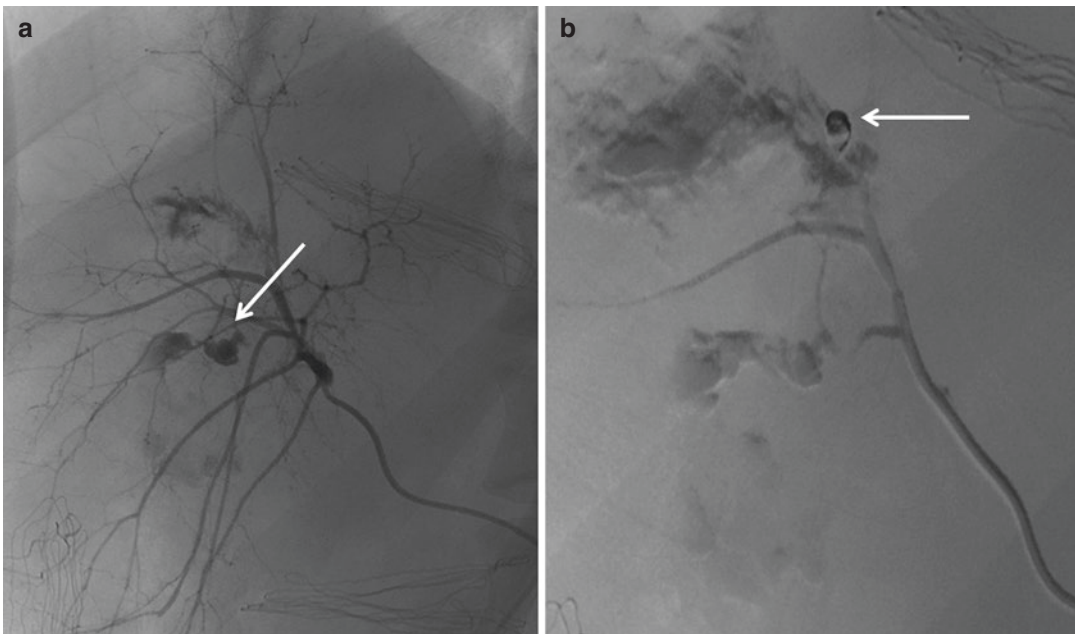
In the same patient of Fig. 14.14, hepatic artery angiography (a) confirms active bleeding, previously identified on CE-CT scans. (b) Trans-arterial embolization achieved with coils (arrow)
